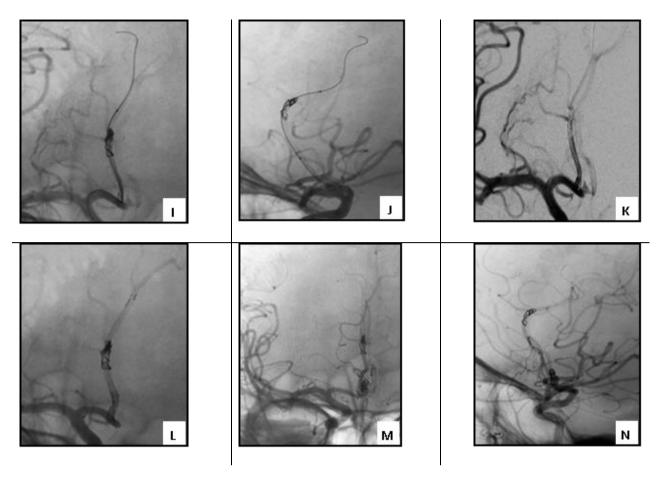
Diagnostic head CT; - B - Brain Angio-CT showing a CoA aneurysm; C, D - DSA right and left ICA demonstrating a CoA aneurysm: E - Partially coil migration to right A2; - F, G - Frontal and lateral view with attempt of coil retrieval; - H - DSA image with distal coil migration and arterial occlusion; -I, J - Microguide and microcatheter passing the coil; K - DSA image showing slightly right A2 repermeabilisation; -L DSA showing total right A2 repermeabilization by coil fixation with a detachable intracranial stent; M, N Frontal and lateral view demonstrating adequate coils occlusion of the aneurysm.
